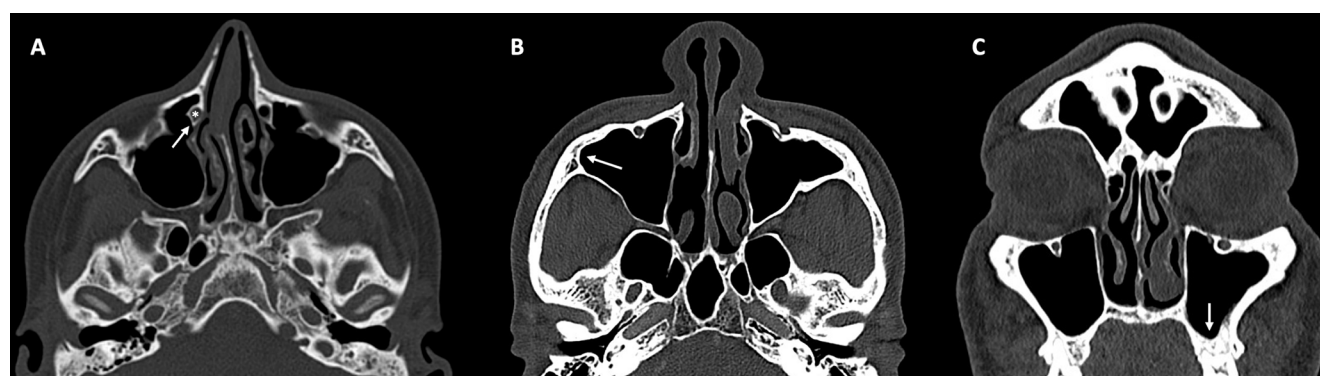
CT scans showing the specific localization of retro-lacrimal, alveolar, and zygomatic recesses. Retro-lacrimal recess (A, white arrow): located between the posterior wall of the lacrimal pathway (*), antero-medial aspect of the natural ostium of the maxillary sinus, and uncinate process; Zygomatic recess (B, white arrow): lateral pneumatization of the maxillary sinus towards the zygomatic bone and located between the superior, anterior, and lateral walls of the MS; Alveolar recess (C, white arrow): inferior pneumatization of the maxillary sinus towards the alveolar process of the maxilla bone, and located between the inferior, anterior, and medial walls of the MS.
